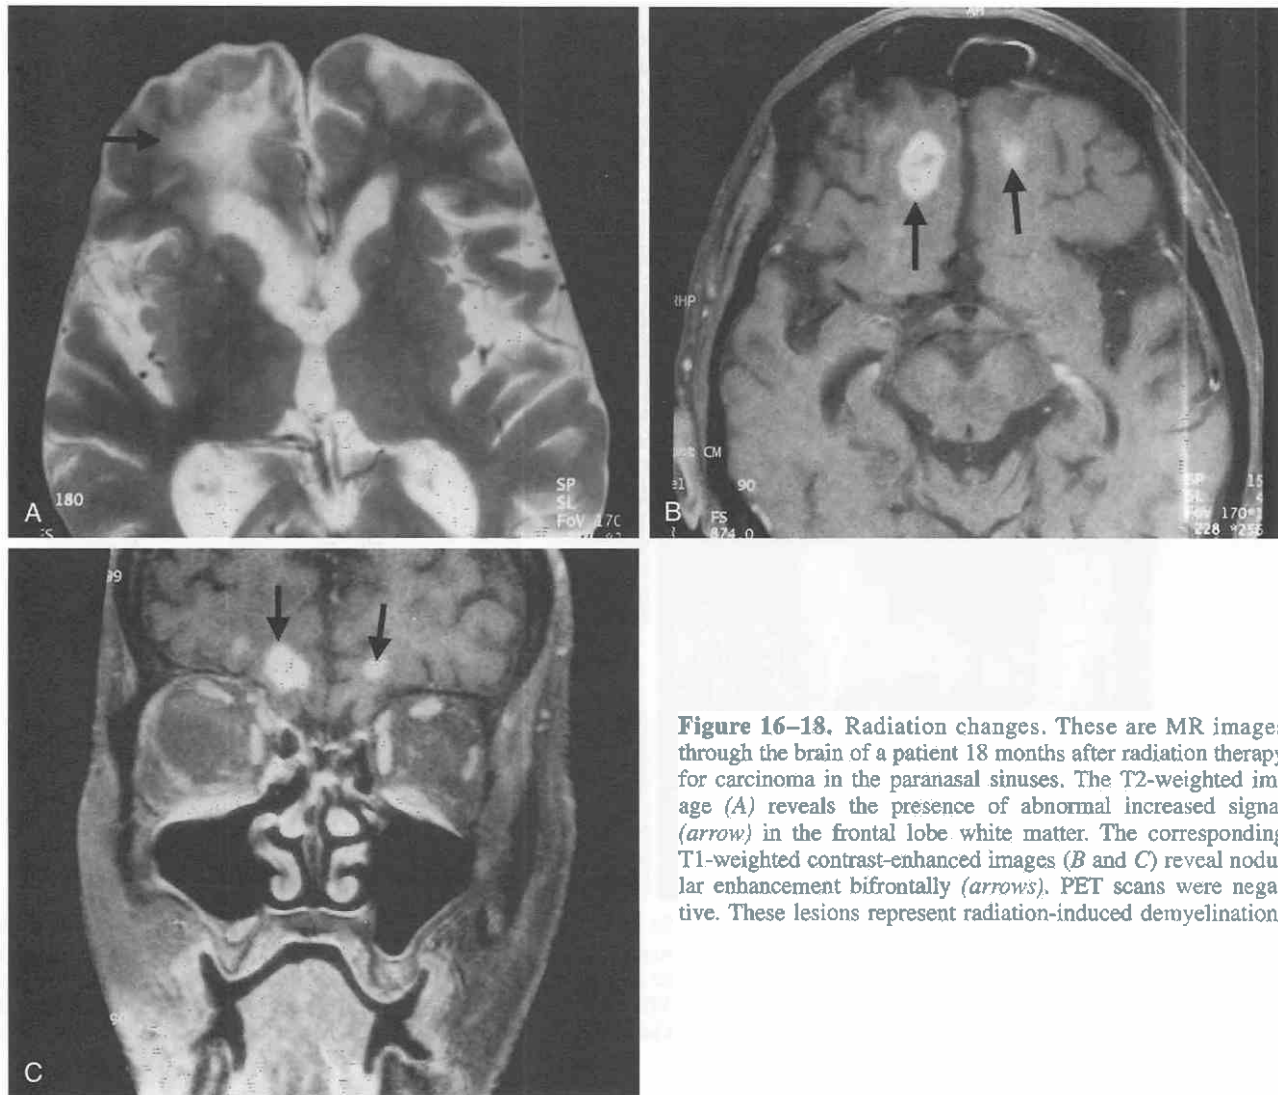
Radiation changes. These are MR images through the brain of a patient 18 months after radiation therapy for carcinoma in the paranasal sinuses. The T2-weighted image (A) reveals the presence of abnormal increased signal (arrow) in the frontal lobe white matter. The corresponding T1-weighted contrast-enhanced images (B and C) reveal nodular enhancement bifrontally (arrows). PET scans were negative. These lesions represent radiation-induced demyelination.
